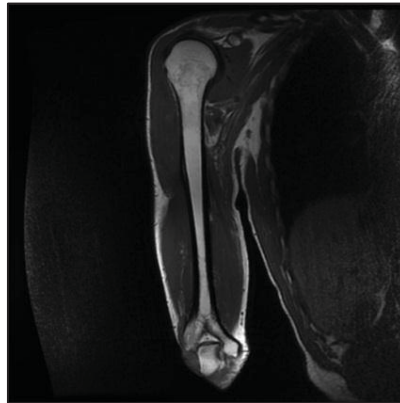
MRI image of the Humerus (152).
